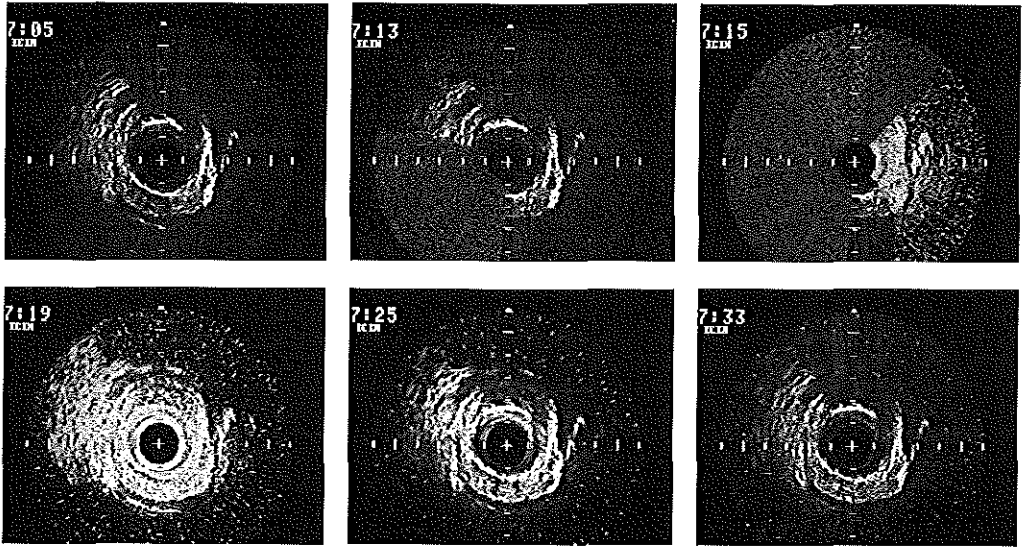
Sequence of ultrasound images showing, from left to right and from top to bottom, in the first image a vessel cross section before spark erosion application. In the second and third image the start and end of the spark erosion period is shown which covers the left half and the top of the cross section. A segment showing increased echogenicity becomes apparent in the non ablated part of the cross section (2 to 6 o'clock position). This echogenicity can be observed in the complete cross section 120 ms after the pulse (fourth image) and has almost disappeared during the next period until 240 ms after the sparking pulse (fifth image). After 400 ms the sixth image looks normal again. Obviously, as explained in the text, at this location proximal of the electrode no ablation effect can be observed after a single sparking pulse.
